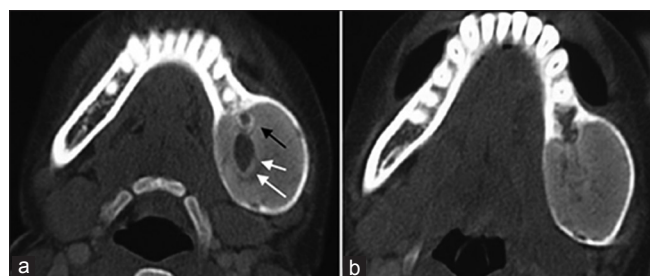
Computed tomography axial views show cortical plate expansion of left body-angle region, (a) hyperdense ground glass internal appearance and focal hypodense oval area (white arrow) within due to previous surgical exploration and anteromedially displaced inferior alveolar canal (black arrow), (b) ground glass internal appearance with central hypodense area
